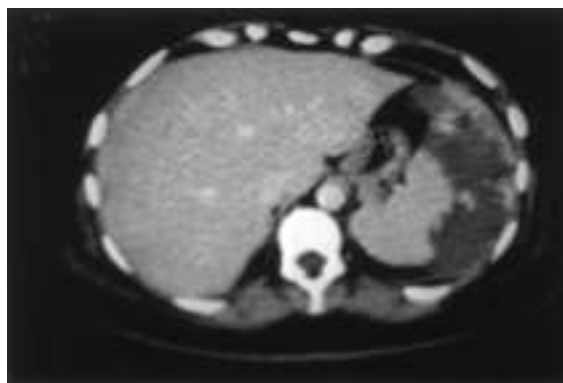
Abdominal CT scan revealed an enlarged ruptured spleen.
